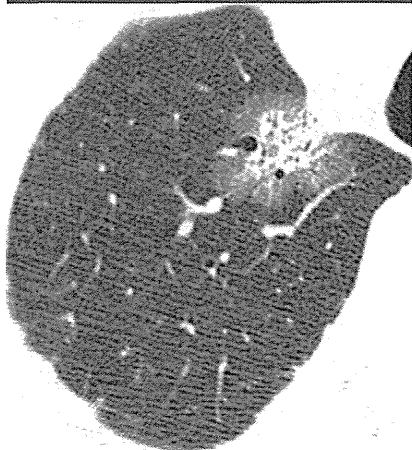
Thin-section CT image of a 27-mm nodule with multiple foci of solid components in a 65-year-old man who eventually died of recurrent disease. Volumetric measurements were total tumor volume, 9.31 cm³; solid tumor volume, 2.77 cm³; and percentage of solid tumor volume, 29.8%.
